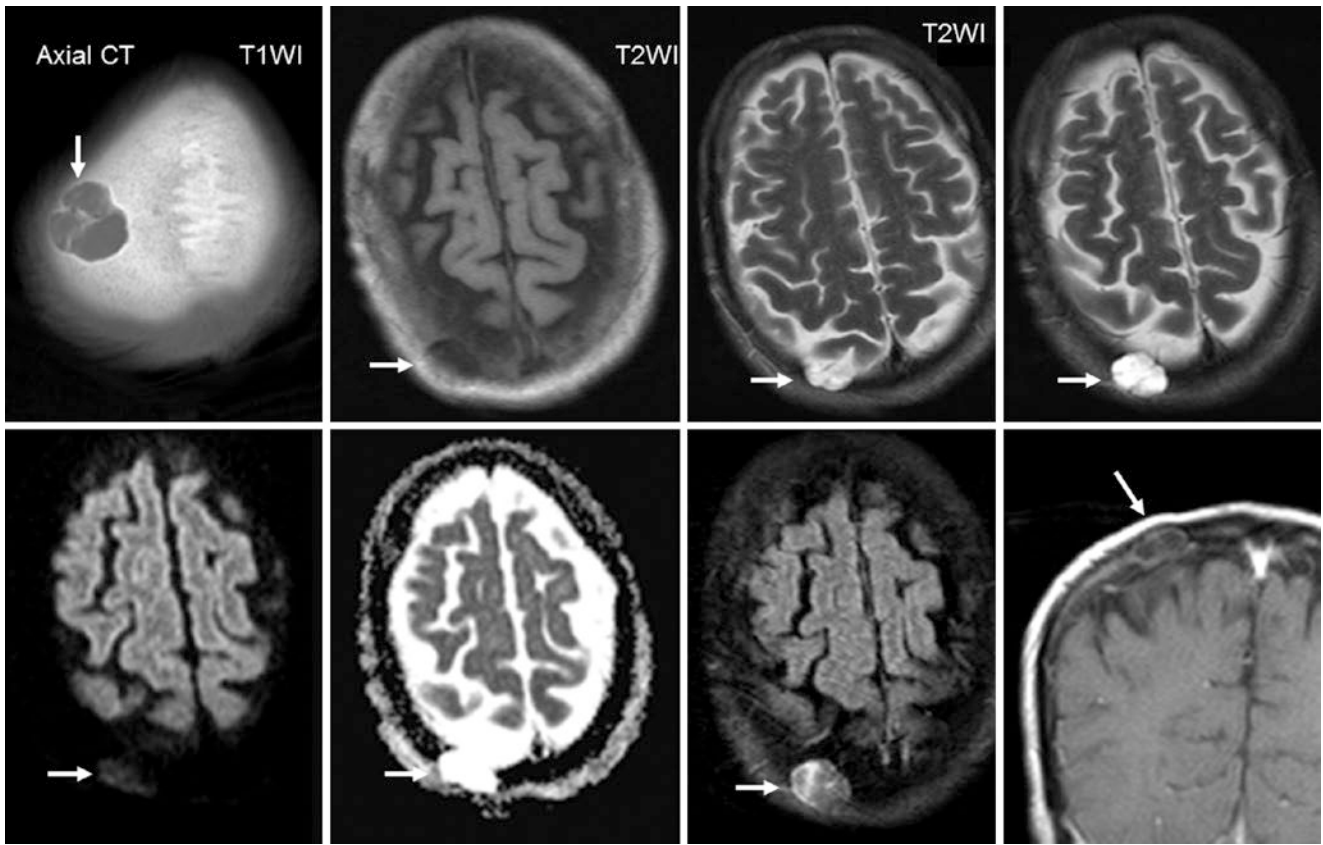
A 48 year old: *Top row*: a septate and partly ossified arachnoid granulation on NECT (*left*) had signal akin to CSF on T1WI (*left middle*) and T2WI (*right images*). *Bottom row*: on DWI, there was decreased diffusion (*left*) with bright signal on ADC map (*left middle*)
